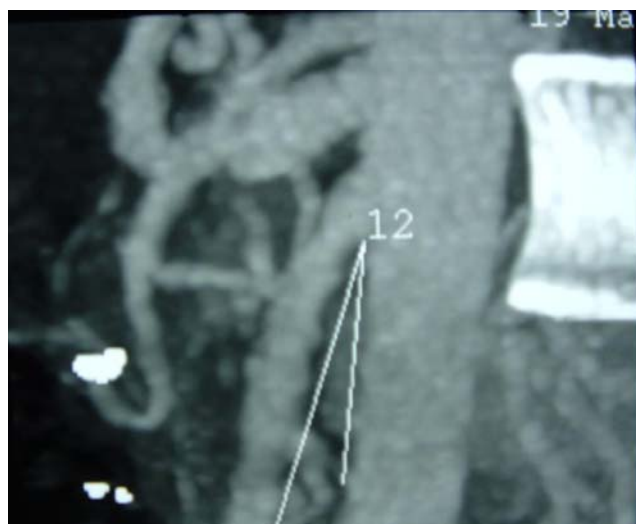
CT angiography showing aortoduodenal angle.
